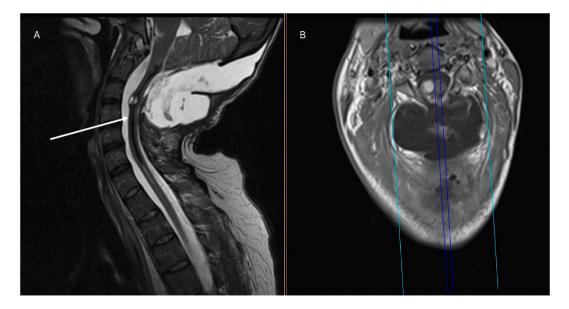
Post-operative MRI. A. Sagittal view of MRI T2WI sequence. White arrow shows the syrinx. B. Axial view of MRI T1WI with contrast, at the level of inferior endplate of C3. The post-op MRI also shows a large pseudomeningocele without compression of the spinal cord.
